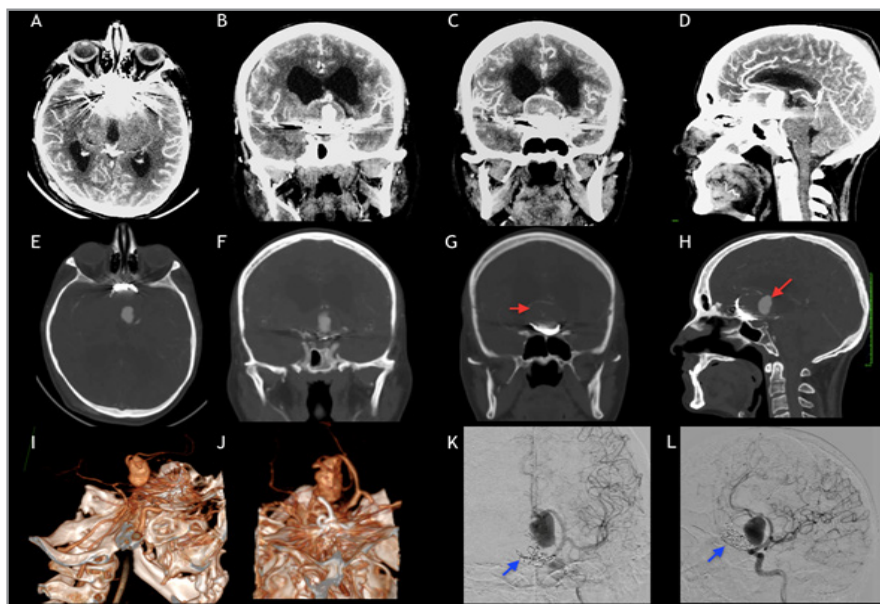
Recanalized Aneurysm, A-D: Shows traditional CTA with metallic artifact obscuring the true dimension of recanalization. B and C identify part of the partially thrombosed wall of the Anterior Communicating Artery aneurysm. E-H: CTAMaR completely reduces the metallic artifact, revealing detailed views of the active aneurysm wall (arrow in G) and the actual aneurysmal sac (arrow in H). I-J: 3D reconstruction of CTAMaR, depicting the recanalized aneurysm and its relationship with the cranial base and Anterior Cerebral Arteries. K-L: DSA reveals the residual aneurysm filling from the left Anterior Cerebral Artery and its relationship with compacted coils (arrow in K and L) at the bottom of the thrombosed wall of the giant aneurysm in frontal image K and left oblique L.
